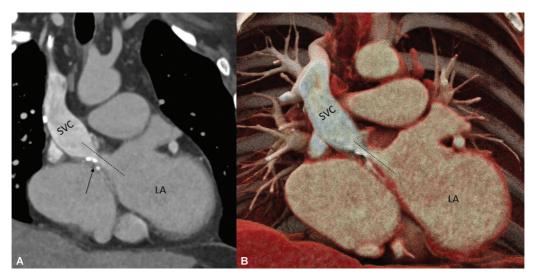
(A) Coronal computed tomography image showing recurrent stenosis of systemic baffle (shown by dotted black line), calcification of the baffle shown by black arrow. (B) Coronal cinematic volume-rendered computed tomography image showing recurrent stenosis of the systemic baffle (shown by a dotted black line). LA, left atrium; SVC, superior vena cava.
